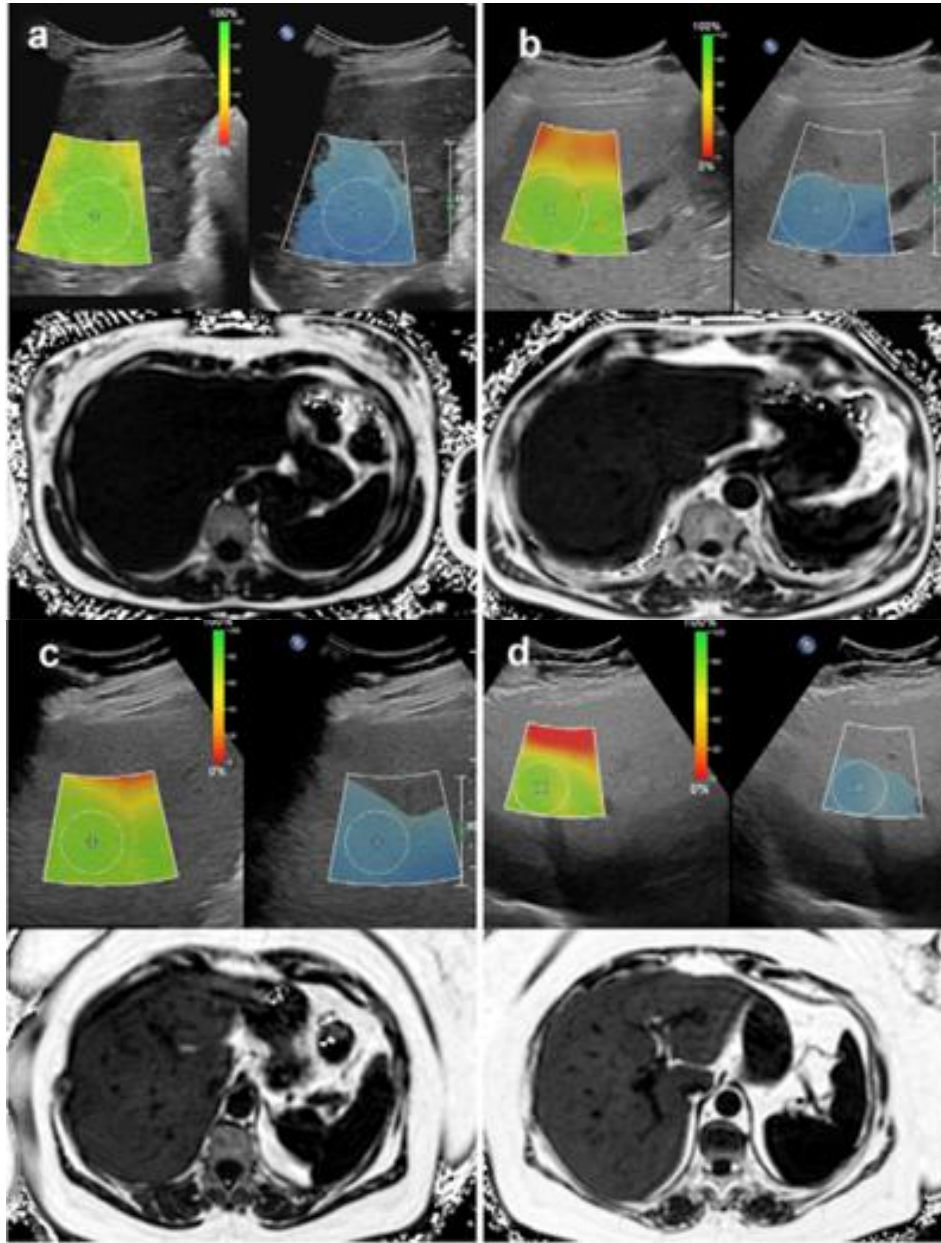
LFQ with corresponding magnetic resonance imaging fat fraction maps. (a) A 75-y.o. female with a median LFQ of 0.57 dB/ cm/MHz and fat fraction of 3.9%, consistent with the absence of steatosis. (b) A 63-y.o. male with a median LFQ of 0.61 dB/cm/MHz and fat fraction of 6.8%, consistent with grade 1 steatosis. (c) A 56-year-old female with a median LFQ of 0.68 dB/cm/MHz and fat fraction of 16.7%, consistent with grade 2 steatosis. (d) A 23-y.o. female with a median LFQ of 0.73 dB/cm/MHz and fat fraction of 21.4%, consistent with grade 3 steatosis (57).
